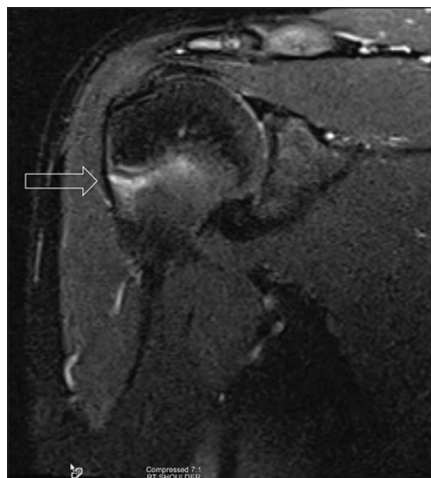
Magnetic resonance image showing increased signal on T2-weighted images (open white arrow).
